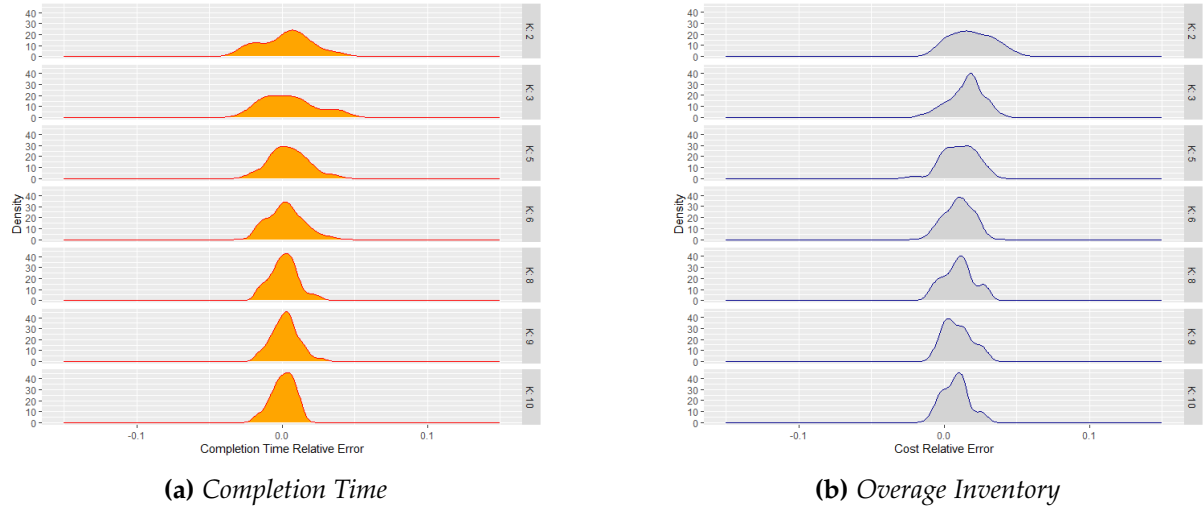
Density plots to determine an adequate number of clusters for CT BO29389
